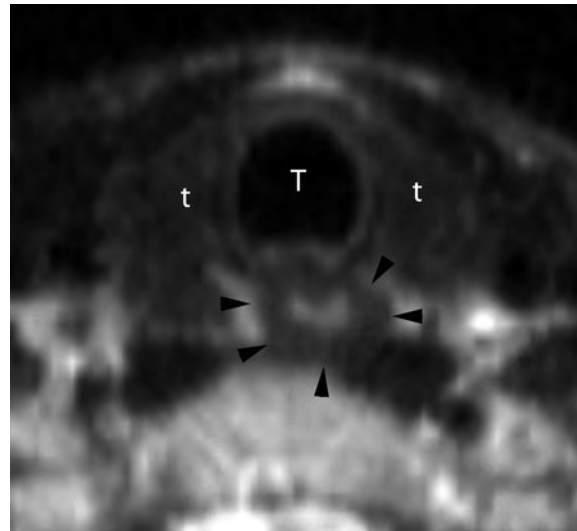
Axial T2-weighted image through the cervical esophagus demonstrating the normal homogeneous low attenuation of the muscular wall of the esophagus (*arrowheads*) in comparison to the hypertintense mucosa centrally and the paraesophageal fat planes laterally. *T* = trachea, *t* = thyroid
